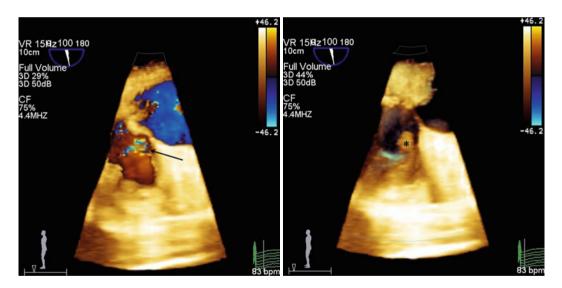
3D TEE color Doppler, short-axis view, showed accelerated flow (*arrow*) in main pulmonary artery caused by the RV outflow tract vegetation
